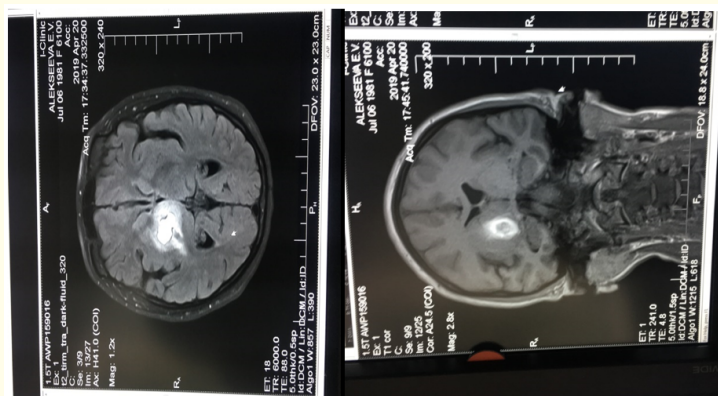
Magnetic resonance imaging of patient A. A subacute thalamus hematoma on the right is visualized.
